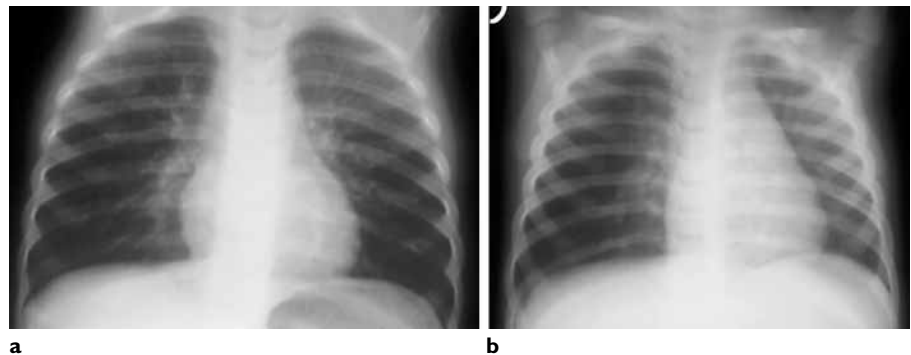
FB impacted in the right mainstem bronchus of a 1-year-old child. Inspiratory chest X-ray normal (a). Obstructive emphysema present during expiration (b).
